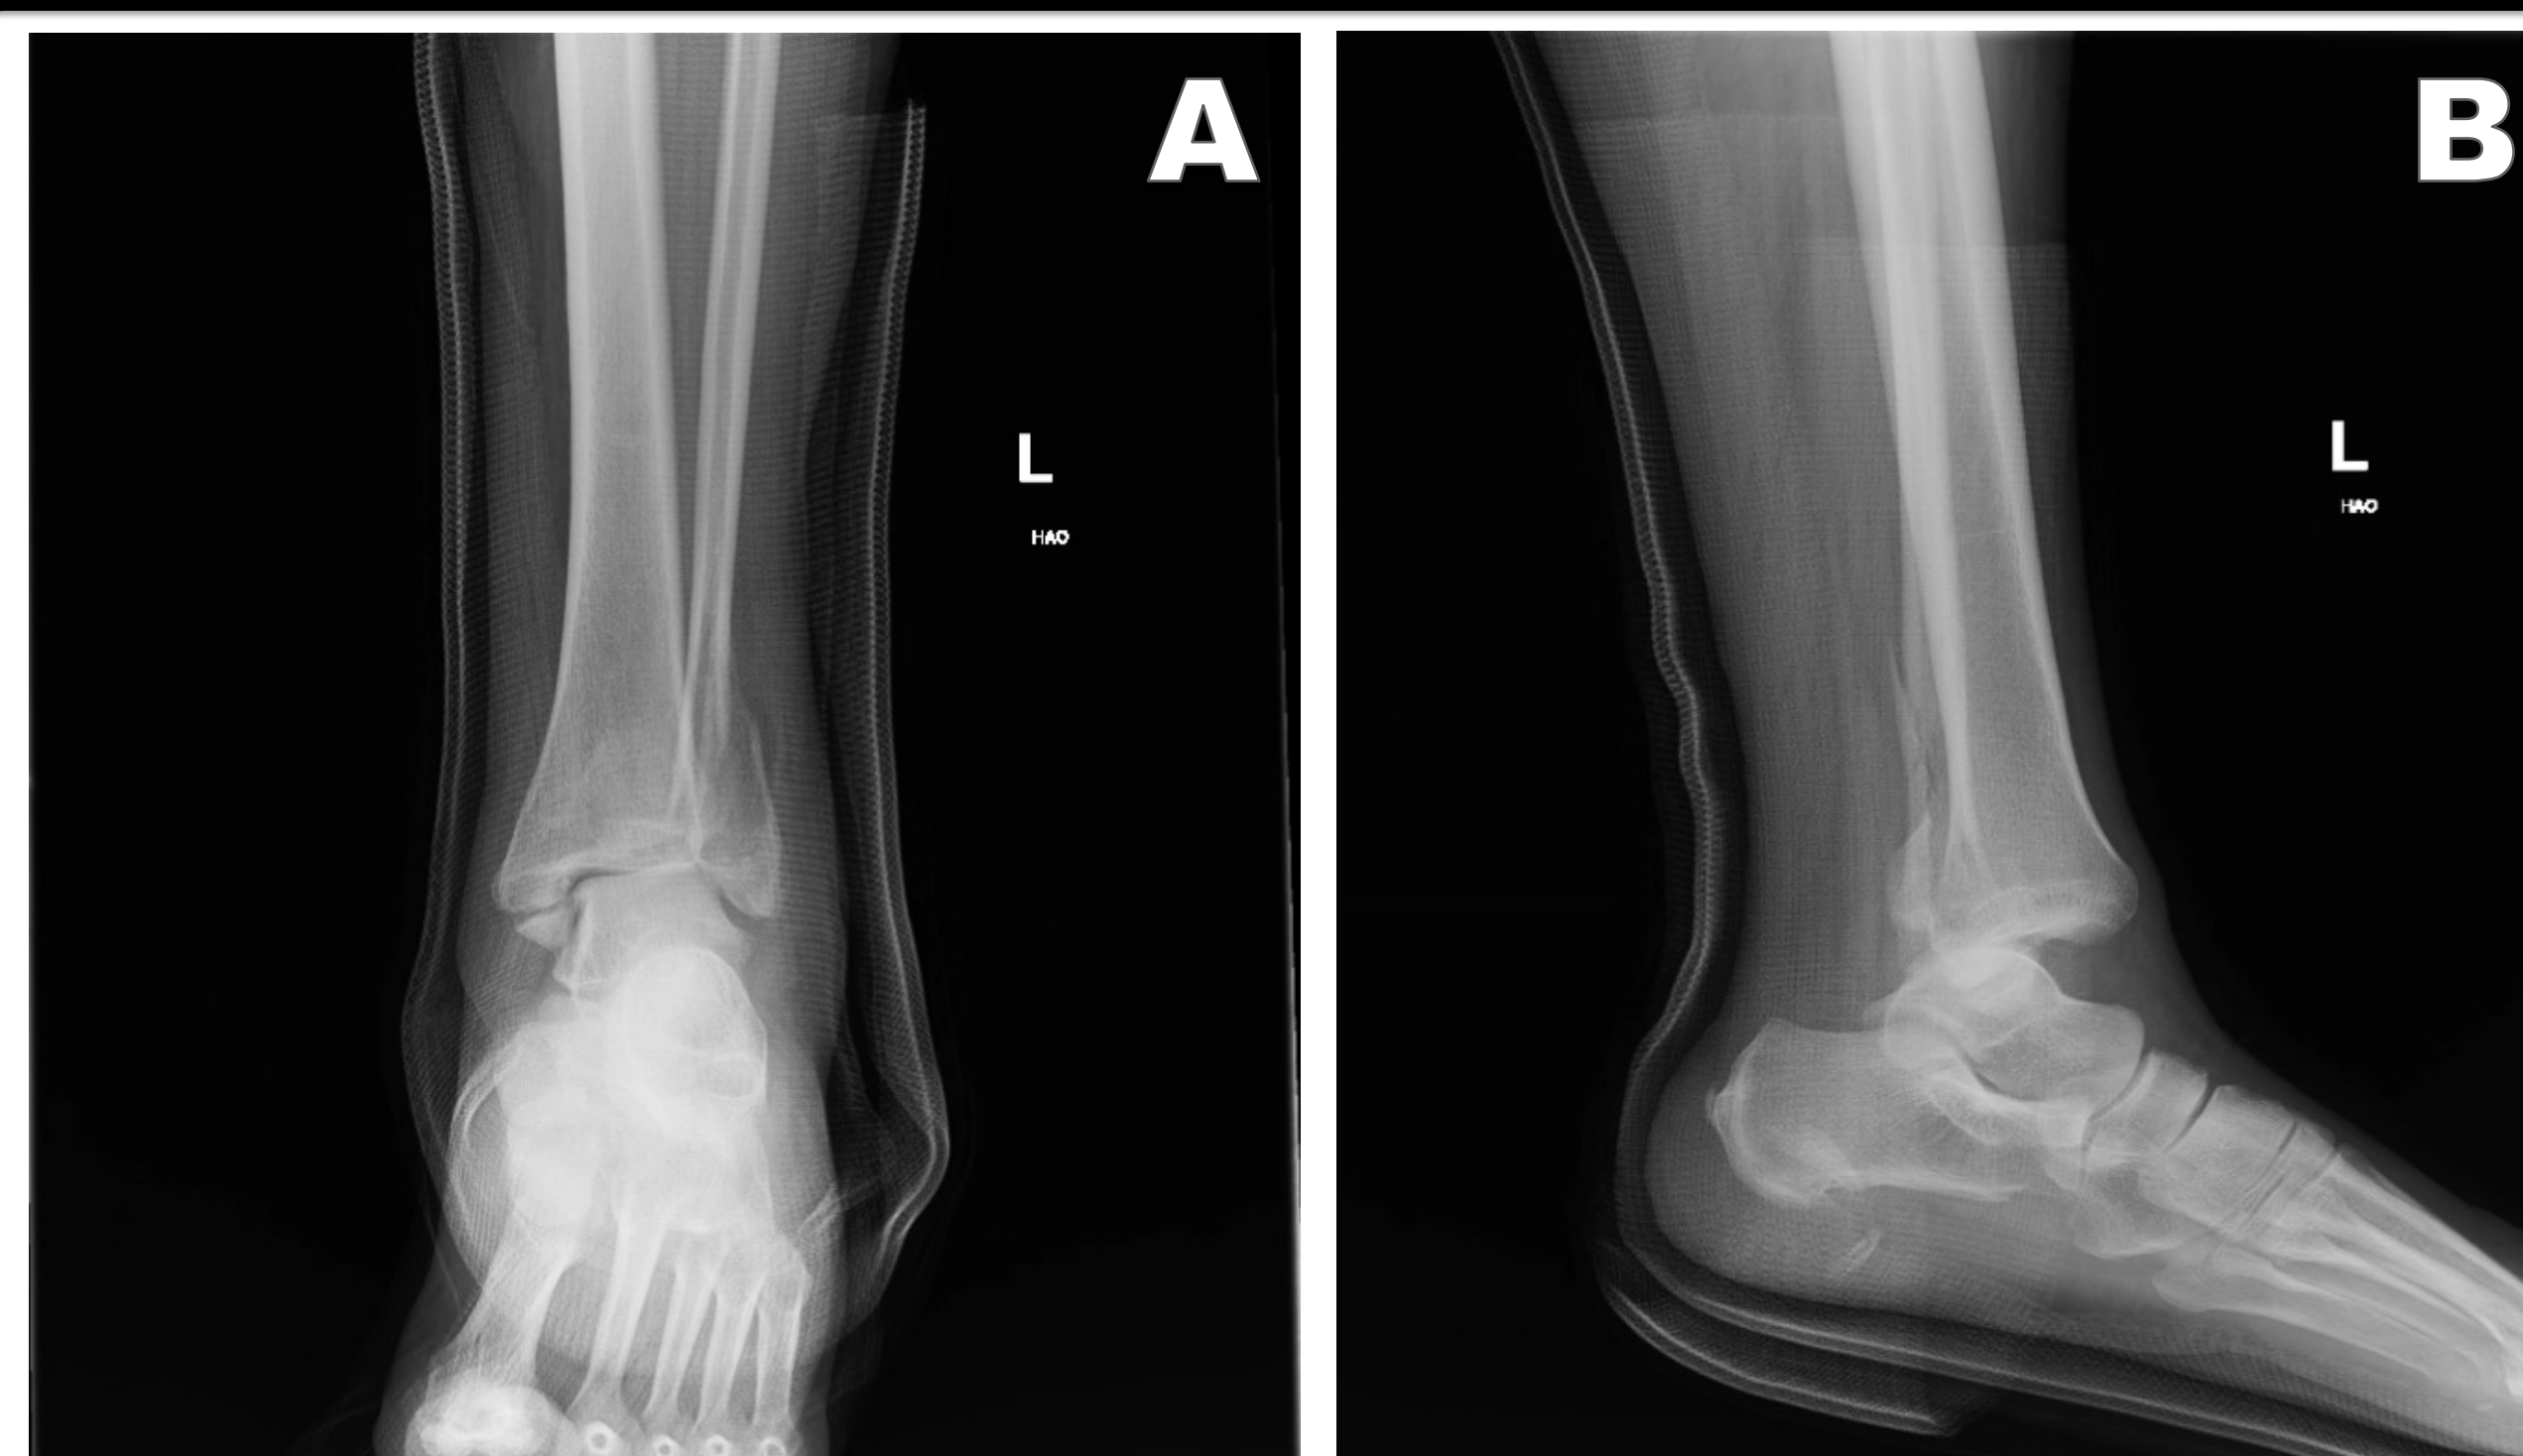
Plain radiographs of the patient's left ankle prior to closed reduction. A, Anteriorposterior view. B, Lateral view.
